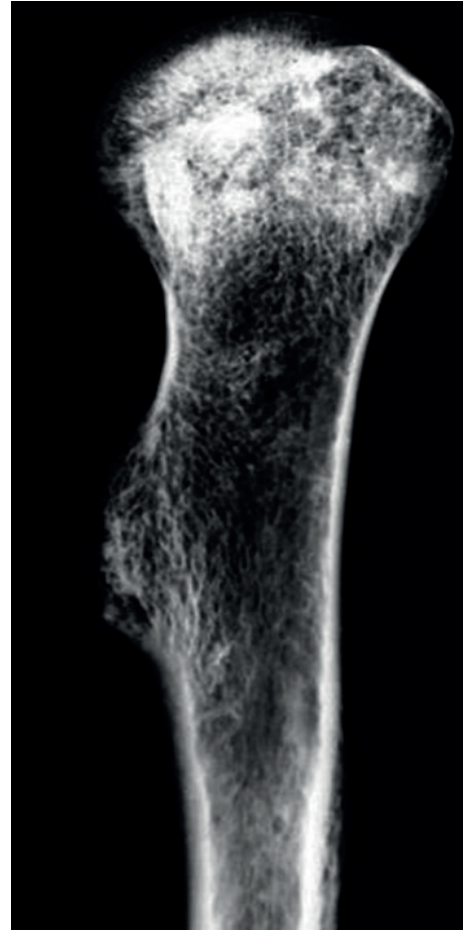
X-rays antero-posterior view of the proximal.
